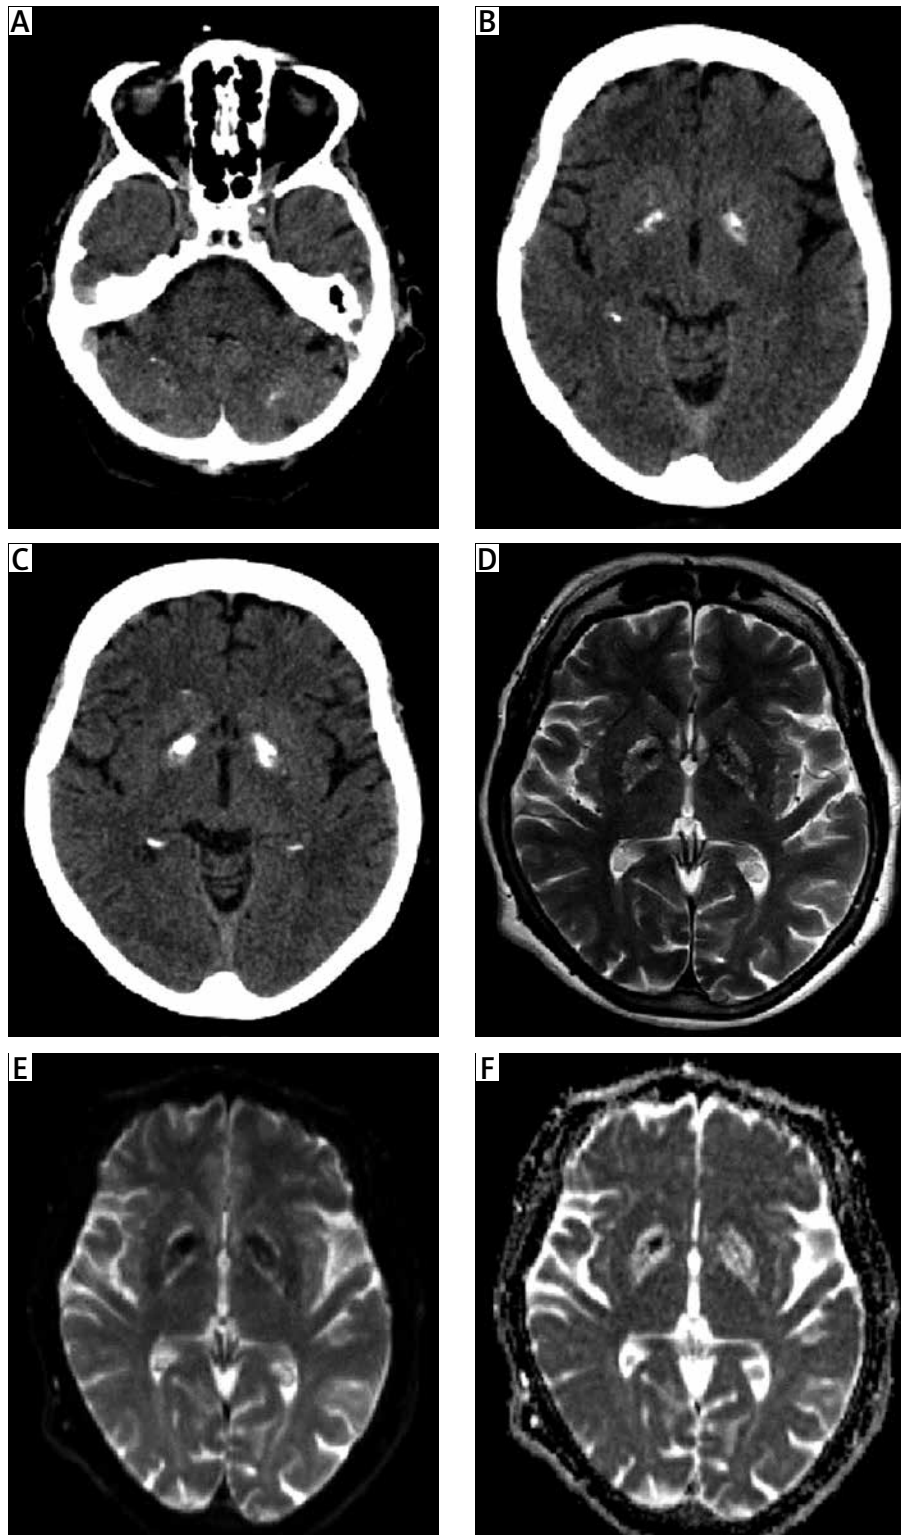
Computed tomography (CT) and magnetic resonance imaging (MRI) findings in patient 3: an axial view shows a marked high density area in the basal ganglia and dentate nuclei of the cerebellum (A-C); MRI calcified areas show hypersignals on FLAIR sequence (C), high- or low-intensity signals on MRI T1-weighted images (D) and dark spots are noted on diffusion weighted imaging (DWI) (E) and the corresponding ADC map (F).
